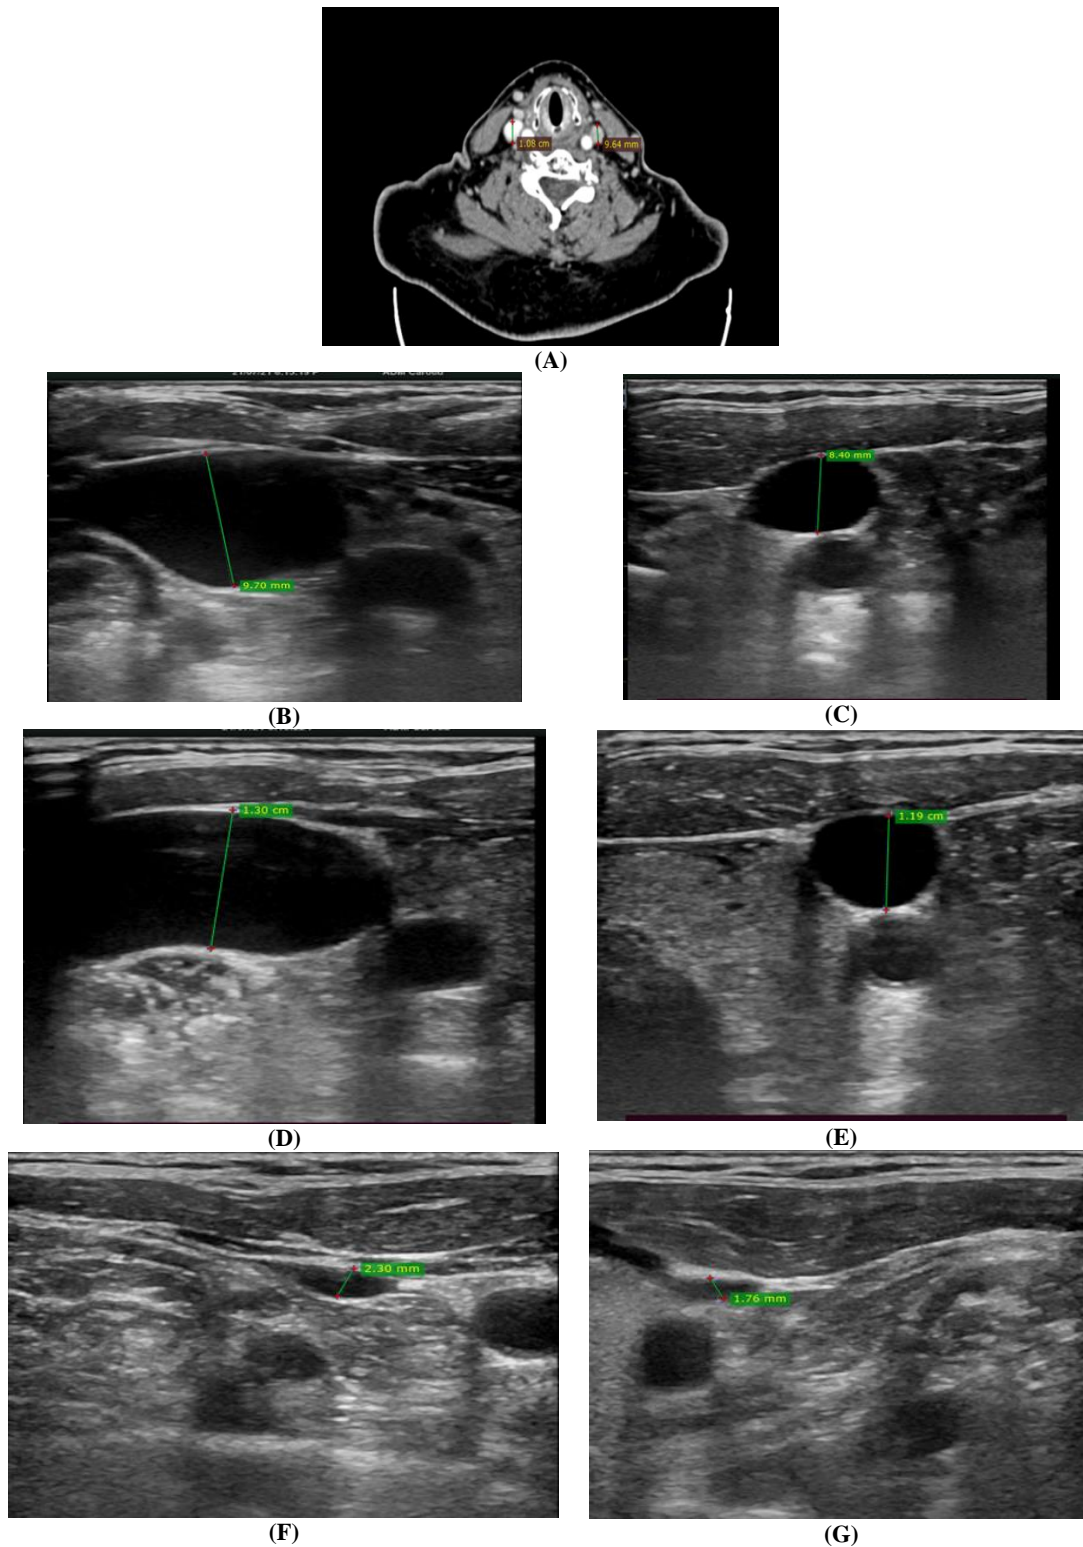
(A) CT neck with IV contrast showing AP diameter of RT IJV which measuring 1.08 cm and AP diameter of Lt IJV which measuring 0.96 cm. (B) AP diameter of RT IJV by U/S at supine position which measuring 0.97cm, (C) AP diameter of LT IJV by U/S at supine position which measuring 0.84cm, (D) AP diameter of RT IJV by U/S with valsalva maneuver which measuring 1.3cm,(E) AP diameter of LT IJV by U/S with valsalva maneuver which measuring 1.19cm,(F) AP diameter of RT IJV by U/S with sitting position which measuring 0.23cm,(G) AP diameter of LT IJV by U/S with sitting position which measuring 0.17cm
